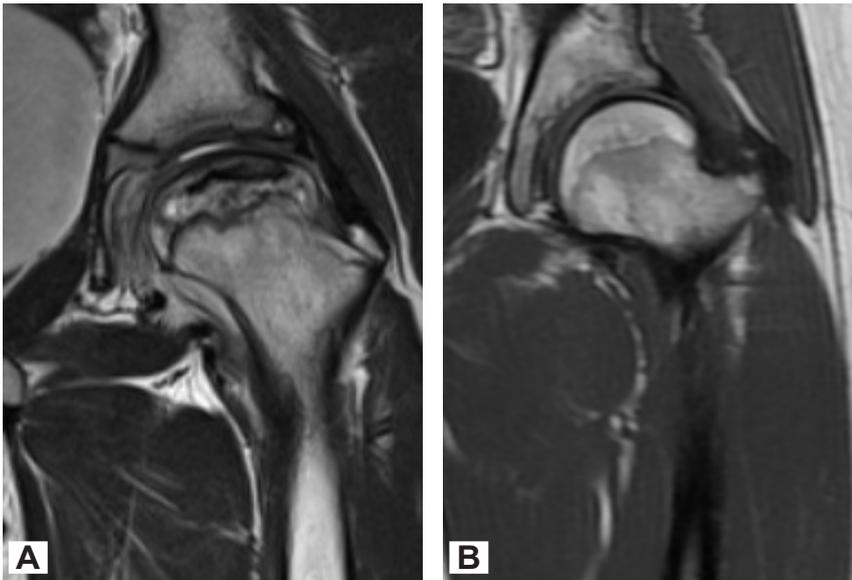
MRI left hip before treatment, subtotal involvement of necrotic process, although lateral pillar is preserved (A); 7 year after treatment. Structure of femoral joint is recovered with satisfied congruency (B)
